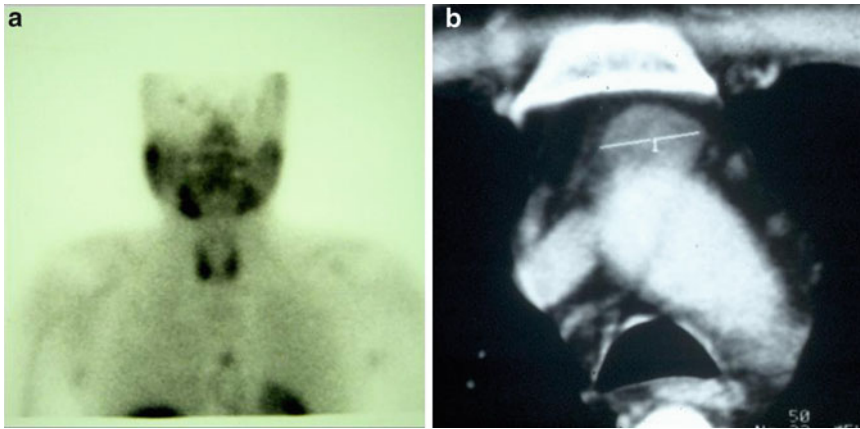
Ectopic mediastinal parathyroid adenoma identified on ^{99m}Tc -sestamibi scintigraphy (a) and on computed tomography (b)
